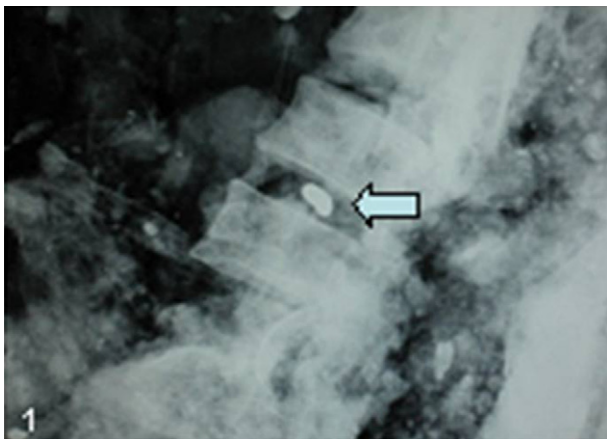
Photograph of CT scan and MRI demonstrating a bullet between two lumbar vertebrae, L4 and L5.
